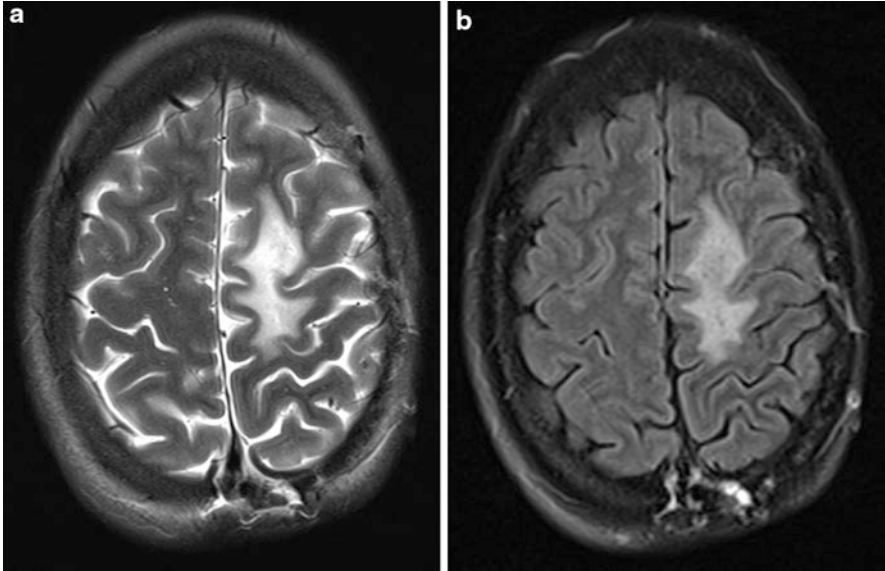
Vasogenic edema. An axial T2-weighted image (a) and an axial FLAIR image (b) demonstrate abnormal increased signal in the subcortical white matter of the left superior frontal gyrus. Notice the “fingerlike” extension of the signal abnormality along the white matter
